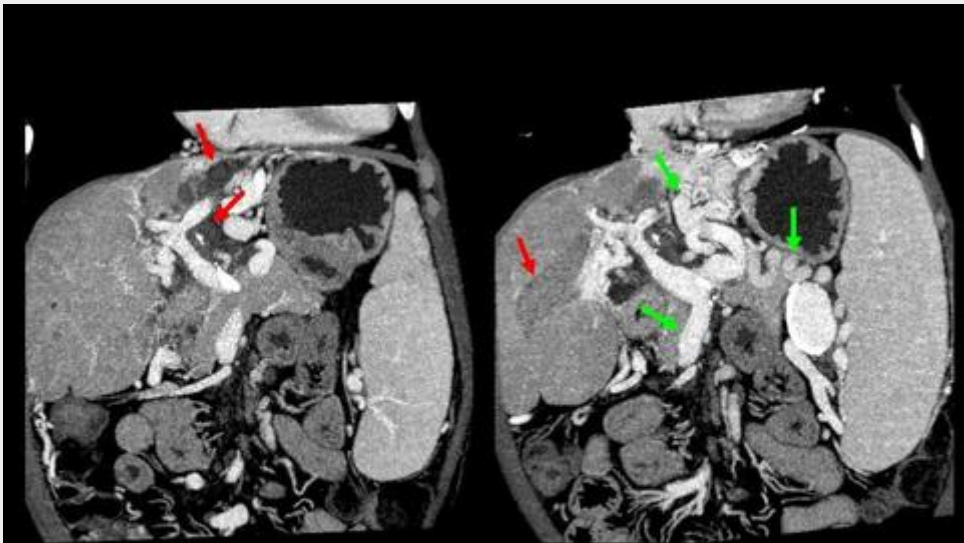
Caroli's Syndrome. Post-contrast abdominal CT. Reformatted oblique MIP images depicting the dilated intra-hepatic bile ducts, some of which filled with calculi (→). Note the splenomegaly and the tortuosity and dilation of the portal, splenic and perigastric veins (→) due to portal hypertension.
